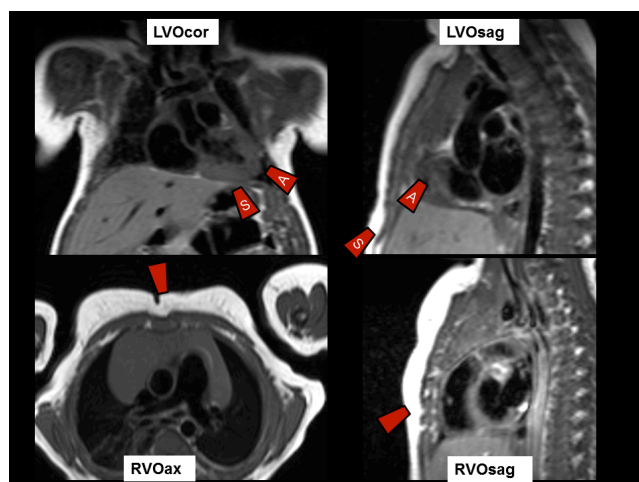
Examples of the approximate superimposed position of the ultrasound probe (red trapezoid) for each outflow tract
